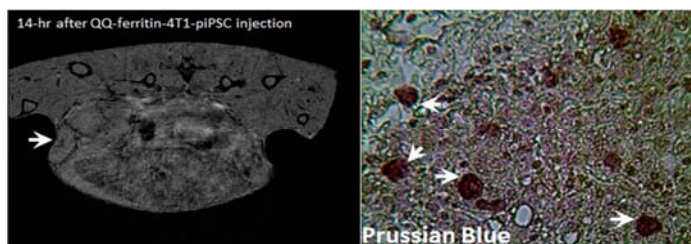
A typical case showing ferritin-labeled 4T1-piPSCs homing to the metastatic tumor 14 hours after ferritin-labeled 4T1-piPSC injection at the left breast. Prussian Blue-positive result was consistent with the MRI result.
